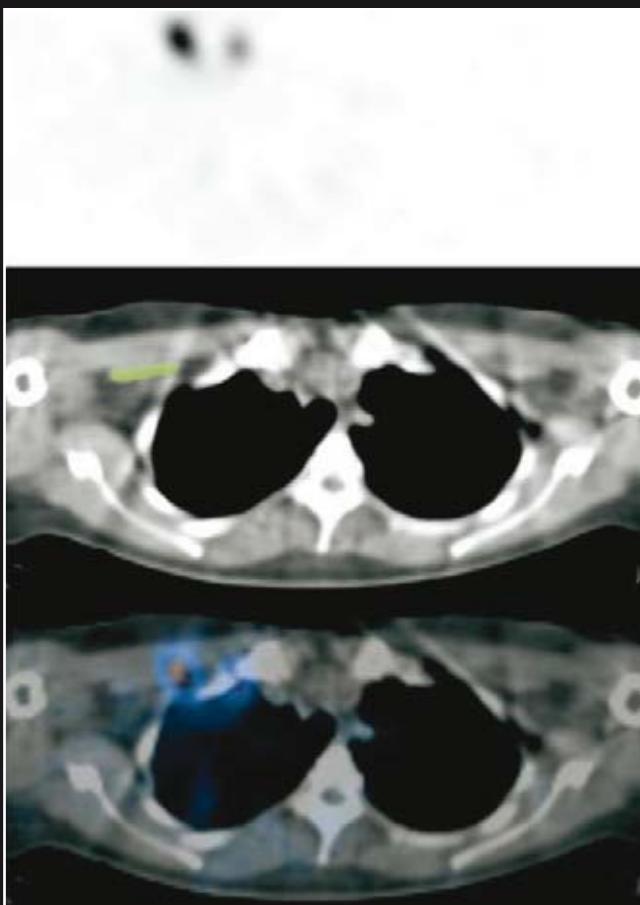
Cross-sectional SPECT image of the breast. Pectoralis minor muscle clearly visible on CT for cutoff between I/I and II/III. Top to bottom: SPECT; CT (pectoralis minor highlighted in green); fused SPECT/CT images, axial plane. Reprinted with permission from Husarik and Steinert. Semin Nucl Med. 2007; 37:29-33.²¹
